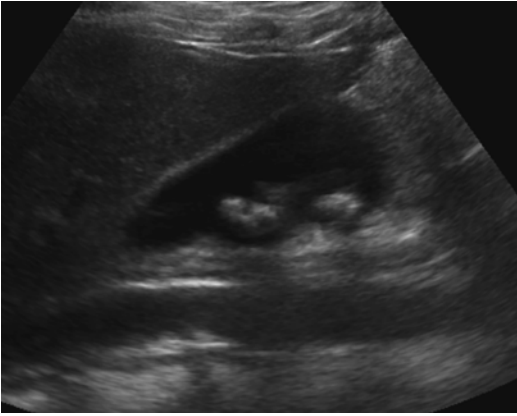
Gray-scale ultrasound demonstrating cholelithiasis with no associated abnormal findings
